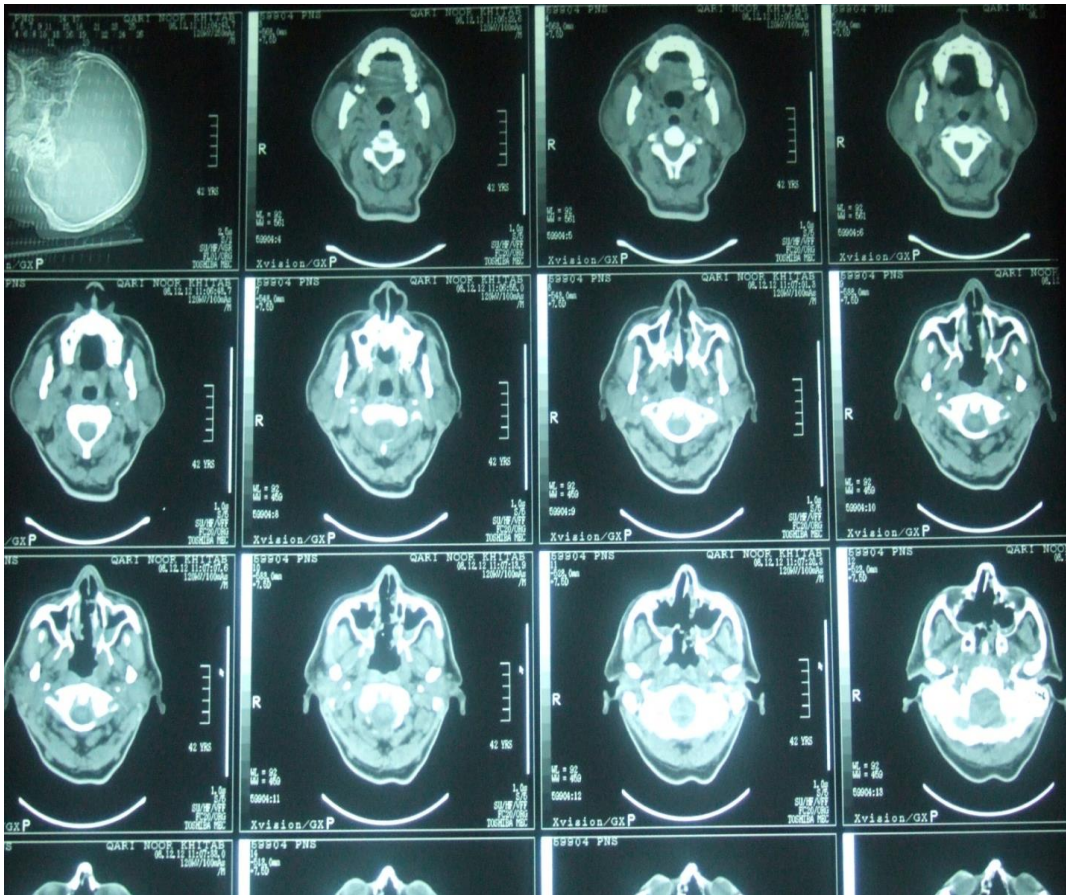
Computed Tomography (CT) scan of the Para Nasal Sinuses (PNS) shows, Mucosal Thickening in both maxillary sinuses and Sphenoid sinuses. Differential diagnosis includes (1) Wegener's Granulomatosis (2) Fungal Infection.
